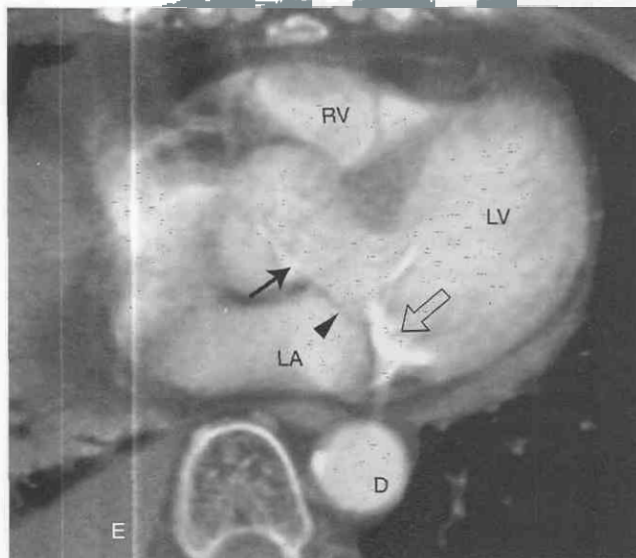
Mitral annulus calcification. Axial contrast-enhanced CT image shows calcification of the mitral annulus (open arrow), which was also identified on chest radiograph. Calcification within the mitral annulus may be difficult to differentiate from calcium in the circumflex coronary artery. A small amount of calcification can be visualized within the aortic valve (arrow). The patient did not have evidence of aortic stenosis. D, descending aorta; E, right pleural effusion; LA, left atrium; LV, left ventricle; RV, right ventricle. The arrowhead points to the mitral valve leaflet.
